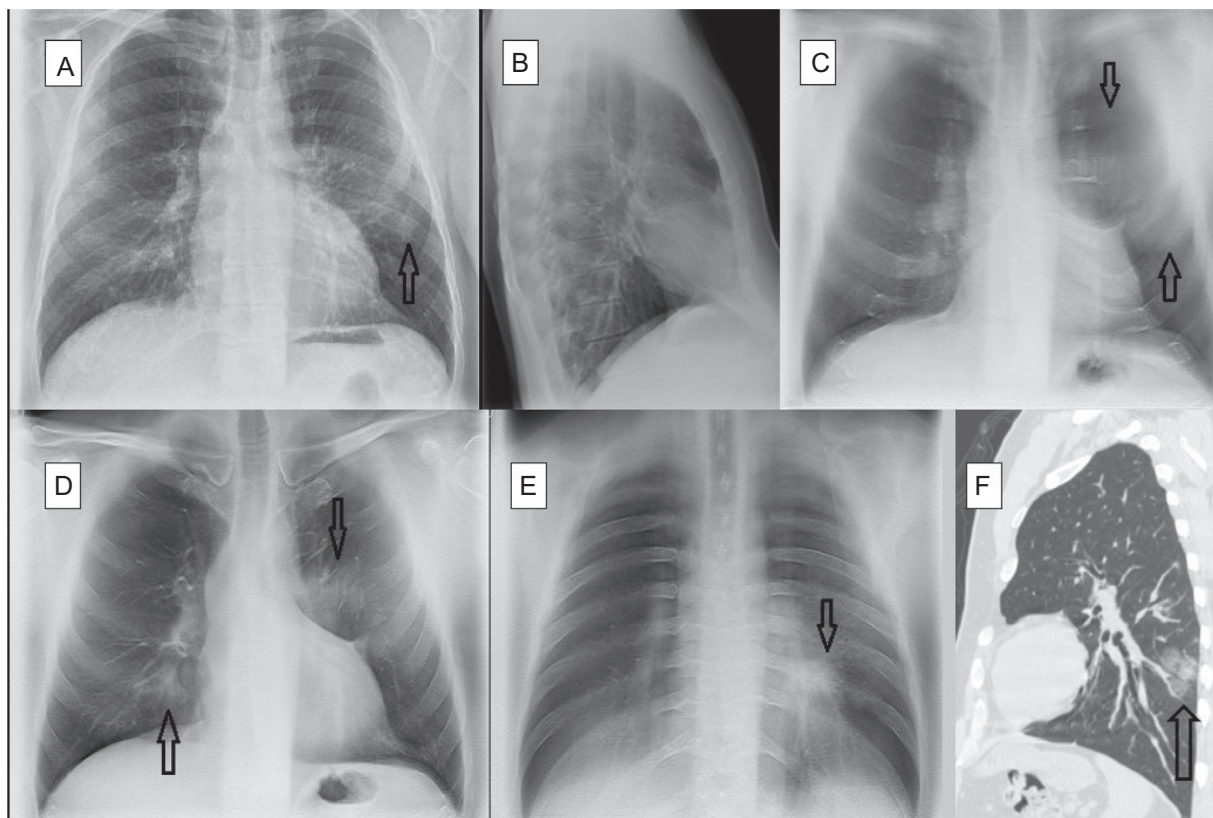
Bilateral COVID-19 pneumonia. A 52-year-old man, family doctor by profession, presented with a 10-day history of cough and myalgia. Dyspnea and fever on examination. Laboratory tests: normal white cell count, ferritin 545.7 ng/mL (>322), and erythrocyte sedimentation rate 53 m/n (0–20). PCR positive for SARS-CoV-2. A—Posterior-anterior chest X-ray: slight opacity in the periphery of the left hemitorax, middle field. B—Lateral chest X-ray with no obvious findings. C—DTS: Image no. 8 (anterior). Extensive opacity in anterior region of left hemitorax (arrows). D—DTS: Image no. 14 (central). Bilateral pulmonary opacities, in the left suprahilar region (arrow) and right lower lobe (arrow). E—DTS: Image no. 36 (posterior). Oval opacity in retro-cardiac region (arrow). F—Non-contrast chest CT scan, sagittal reconstruction. Oval opacity in the periphery of the left lower lobe (arrow).
